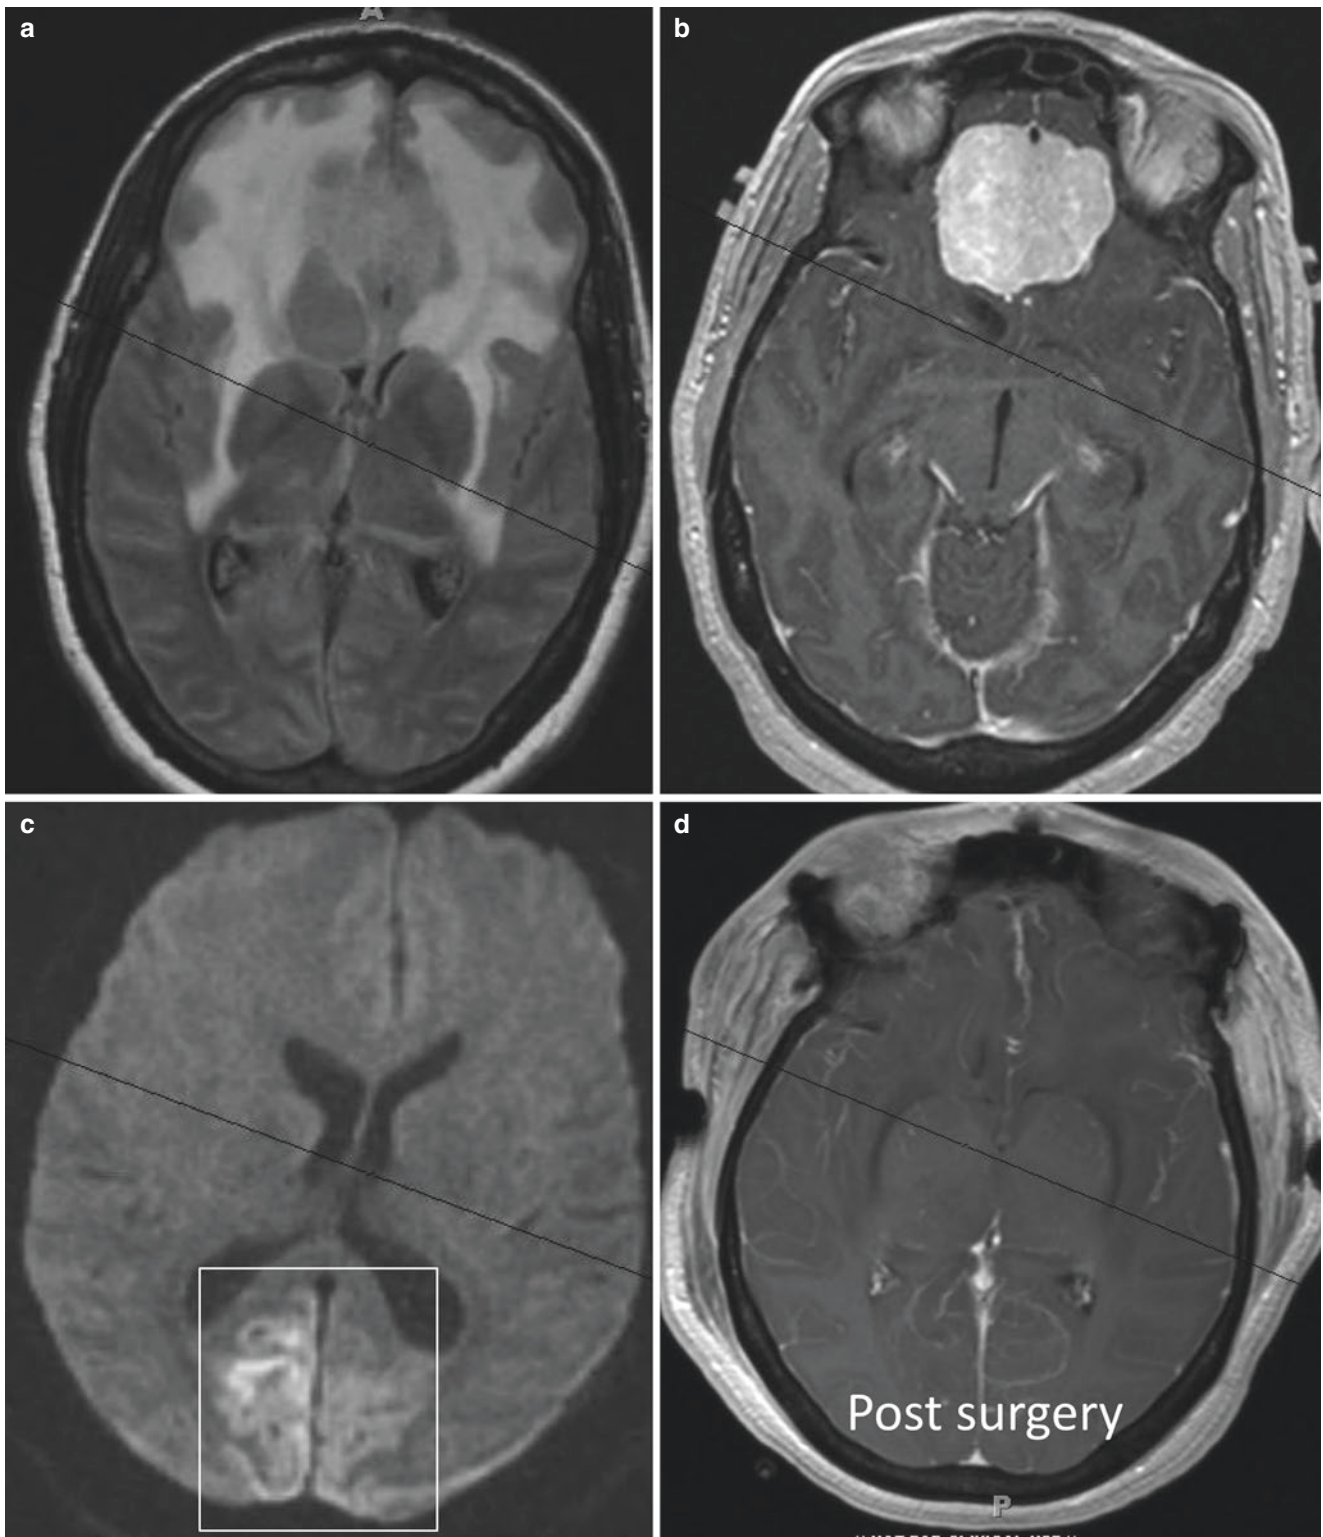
(a) Preoperative T2-weighted magnetic resonance imaging (MRI) scan, demonstrating significant bilateral frontal lobe edema tracking posteriorly along the white fiber tracts. (b) Preoperative T1-weighted MRI scan with contrast, demonstrating olfactory groove
